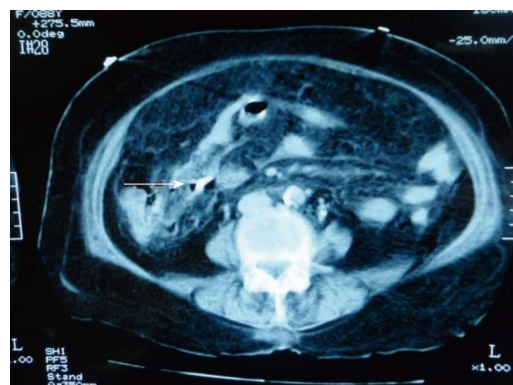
There is a lesion in bone density at the right hypogastric region on the abdominal computed tomography (arrow).
